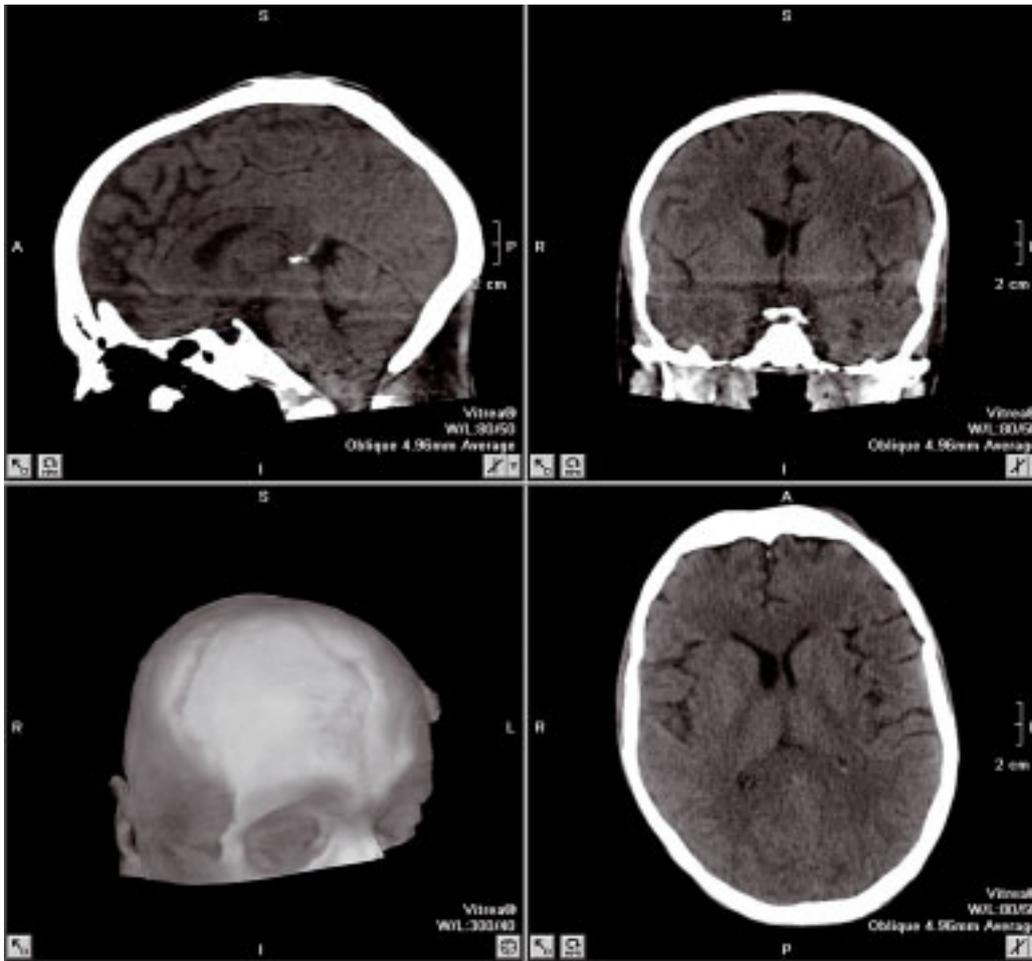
Unenhanced, single-rotation, volume cranial CT consisting of 320 x 0.5 mm axial sections. This allows for high-quality multiplanar reformation.
